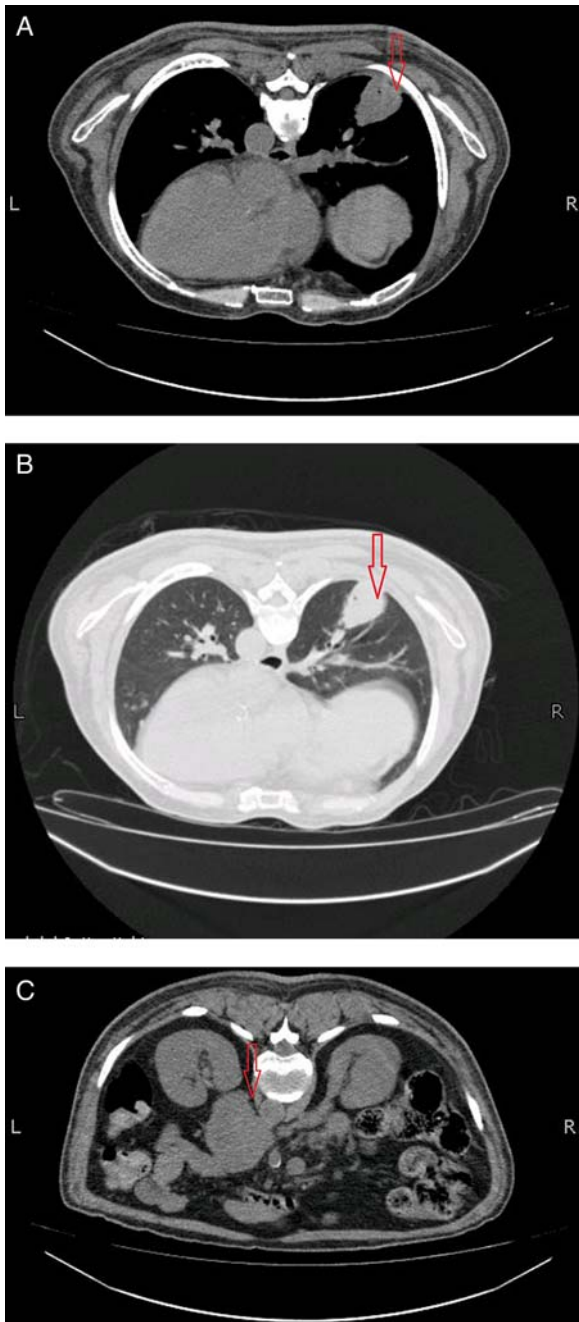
(A) CT of the chest mediastinal window showing right lung mass. (B) CT of the chest lung window showing right lung mass. (C) CT of the abdomen showing retroperitoneal mass.
